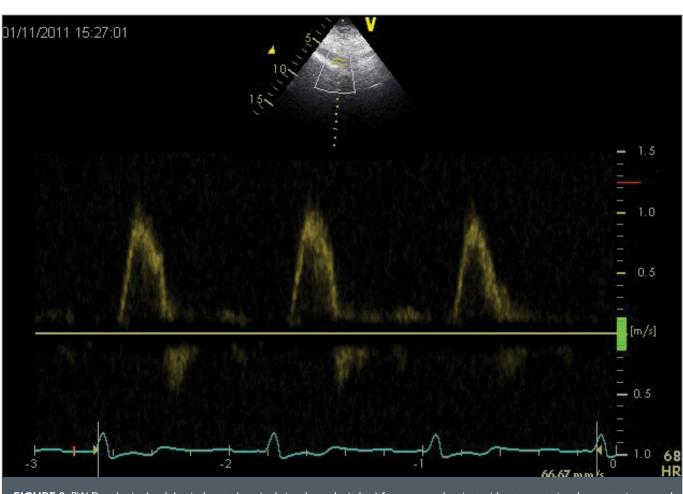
PW Doppler in the abdominal aorta (acquired via subcostal window) from a normal patient without coarctation demonstrating normal triphasic pulsatile flow. This flow pattern excludes the presence of significant coarctation.
